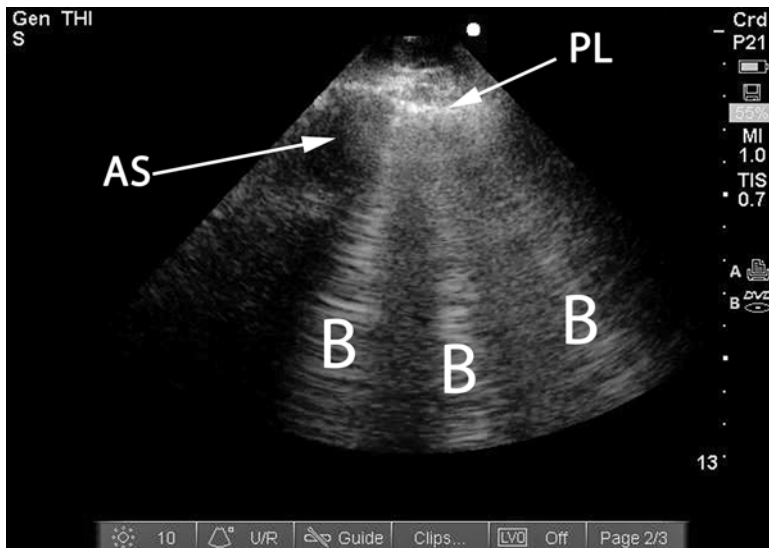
B-lines on thoracic ultrasound. Patient with SAH and severe neurogenic pulmonary edema. *PL* pleural line, *AS* acoustic shadow of rib, *B* B-lines, extending from pleural line to edge of screen
